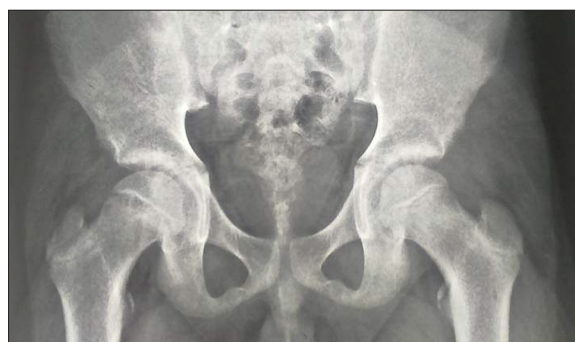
Frontal radiograph of the pelvis taken six months before showing a widening of the proximal right femoral physis.
